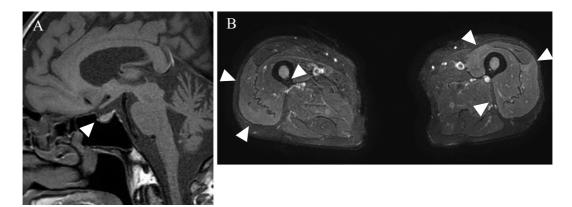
The findings of magnetic resonance imaging at the pituitary gland and quadriceps muscle. (A) T1-weighted imaging of the pituitary gland showed no obvious abnormalities in the anterior pituitary gland (arrowhead). (B) Fat suppression T2-weighted imaging of the thigh revealed diffuse high intensity at the quadriceps muscle (arrowheads).
